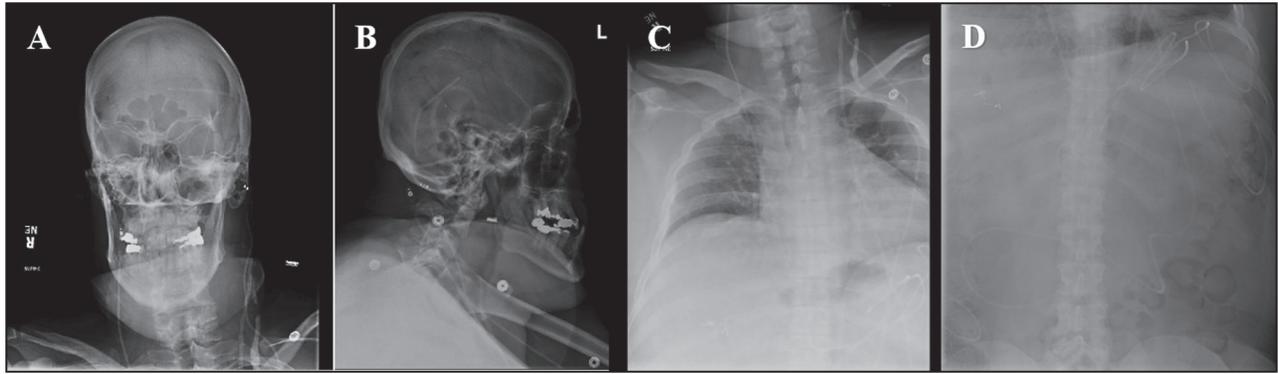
(A–D) Preoperative X-ray shunt series displaying the course of ventriculoperitoneal shunt as well as containment of the peritoneal catheter of the shunt in the anterior compartment of the peritoneal cavity
